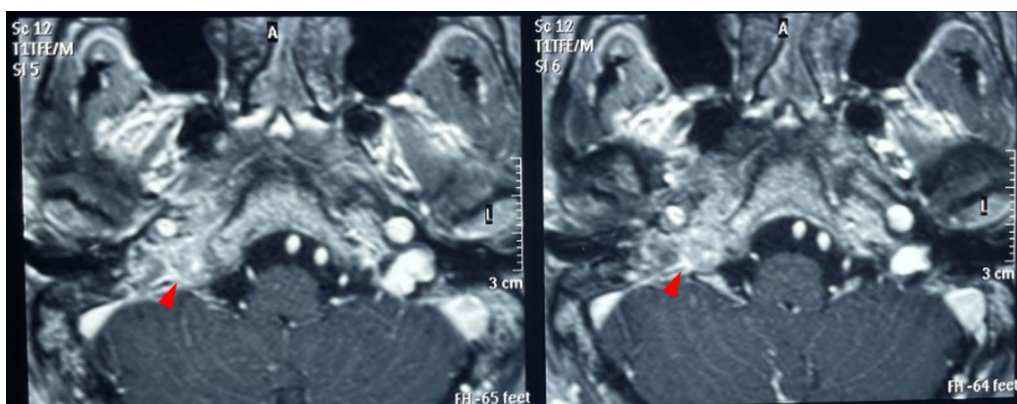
Magnetic resonance imaging demonstrates patchy, heterogeneous enhancement in the region of the right petrous bone and jugular foramen
